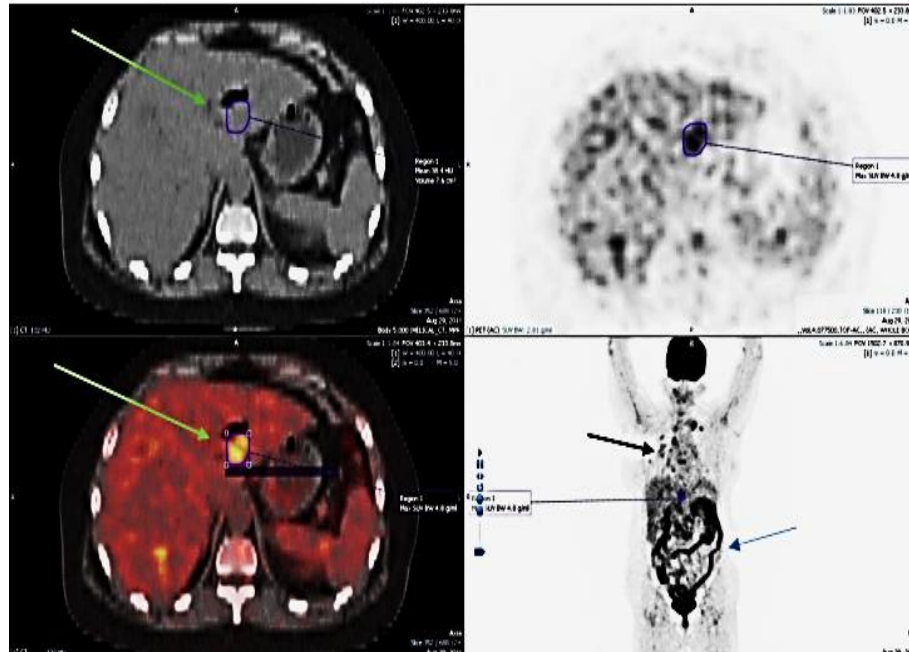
A 40 years old known CA ovary patient presents with raised CA-125 level, showing metabolically active areas in liver (green arrows) with higher SUV value than background on PET/CT scan, these are not well appreciated on CT. Black arrow showing metabolically inactive pulmonary nodules. Normal bowel uptake shown by blue arrow.
